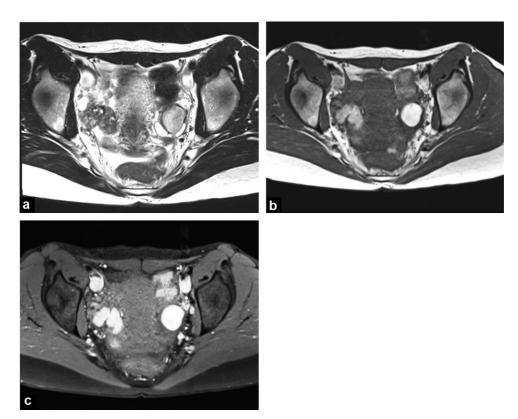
Endometrioma of the left ovary on MRI. Intermediate signal intensity on T2-weighted MR image (shading) (a), high signal intensity on T1-weighted images without (b) and with fat saturation (c).
